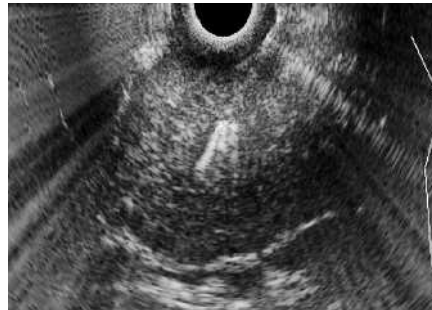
Endoscopic ultrasound-guided fine-needle aspiration of the tumor mass.
